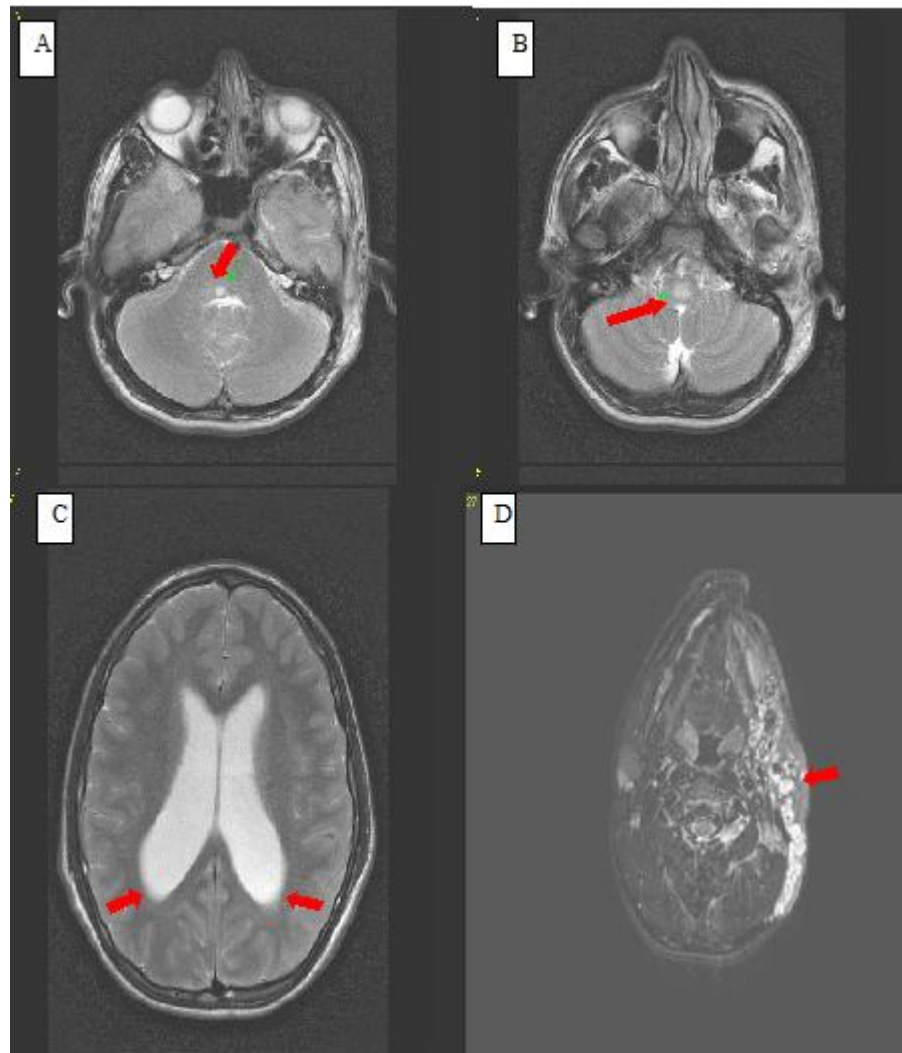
MRI scan (axial view) showing spongiform gliose in the brainstem (A; B) and hydrocephalus (C); plexiform neurofibroma in the face (D) (NF1 Individual Code 001).
